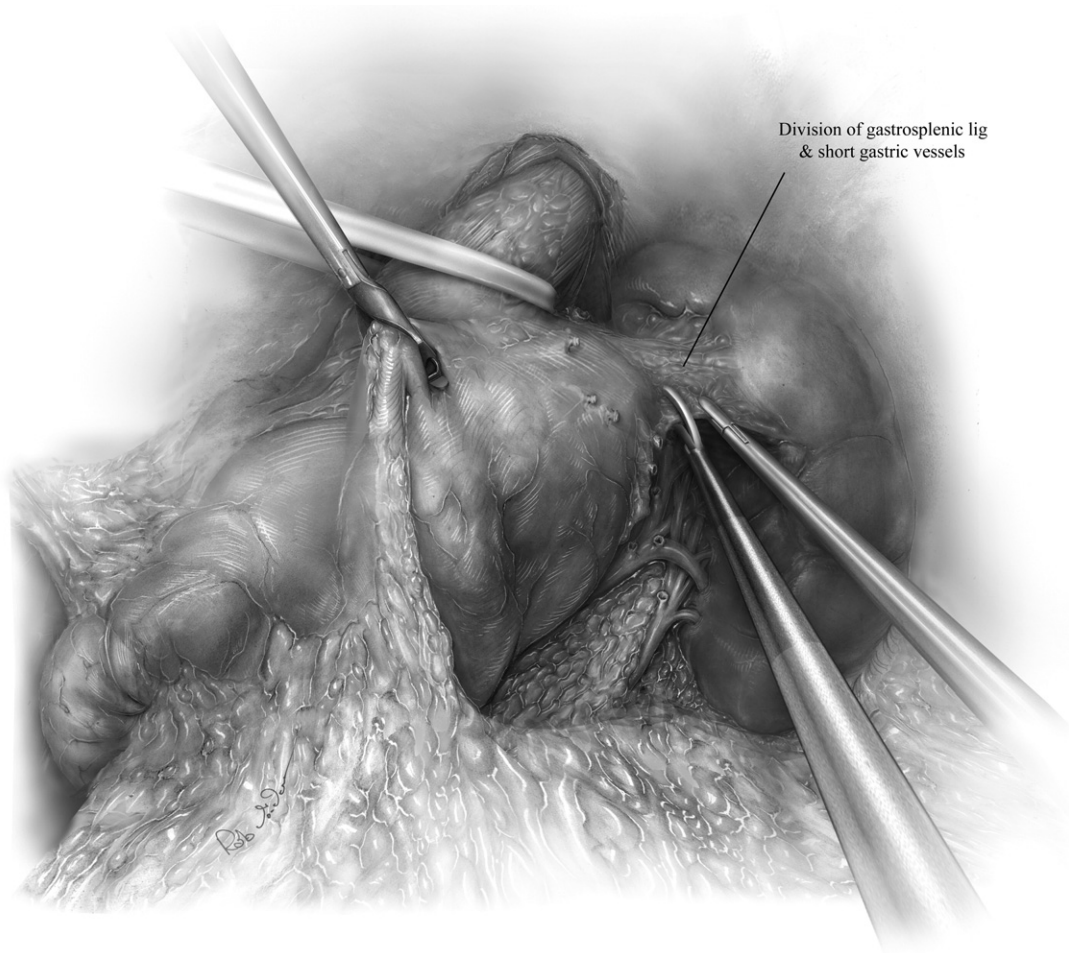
Division of the short gastric vessels. The stomach is grasped by the surgeon through the third port (the epigastric location) and reflected inferiorly and to the patient's right, thus exposing the greater curvature of the stomach. The gastrosplenic ligament is grasped through the second (retracting) port and lifted anteriorly and laterally. This exposes the short gastric vessels, which can be taken with an ultrasonic dissector or other cutting/sealing device. The short gastric vessels should be taken from a point about a third of the way along the greater curvature up to and including the highest short gastric vessels. Diaphragmatic and retroperitoneal attachments of the fundus should also be divided with this exposure. Care should be taken to preserve the gastroepiploic arcade.
